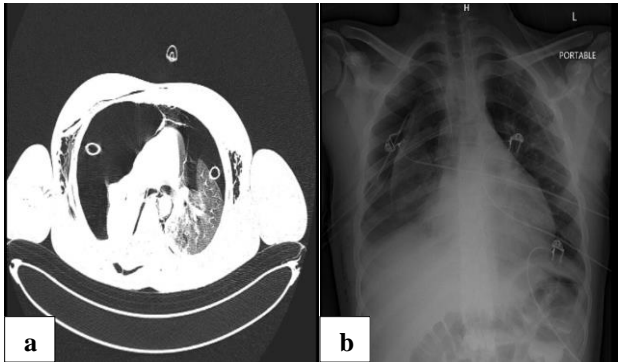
(a) CT chest and (b) CXR post-ICD insertion showing persistent pneumothorax with surrounding surgical emphysema.
